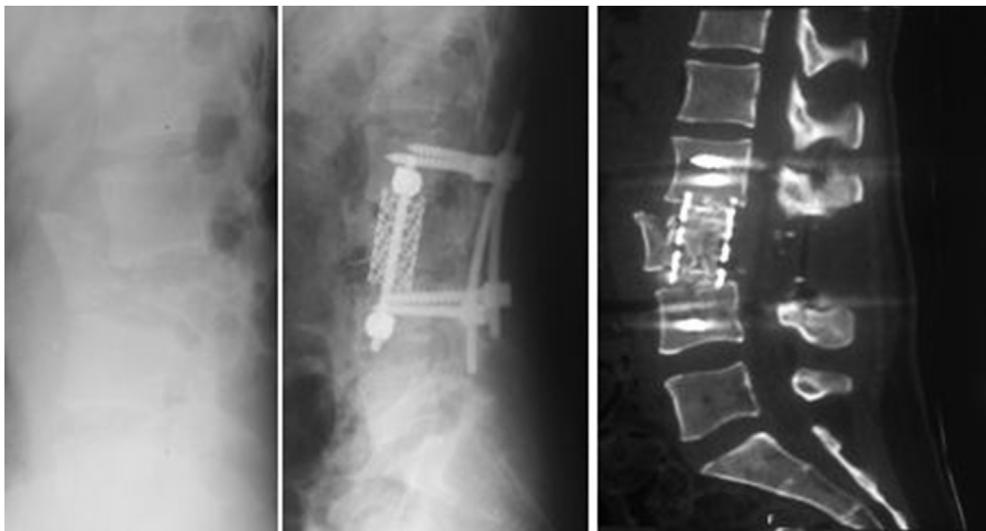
Anterior reconstruction was used to reconstruct a severely comminuted L3 fracture and keep the instrumentation short segment and save mobile lumbar levels; Follow up CT scan shows maintenance of lumbar lordosis and incorporation of graft.
